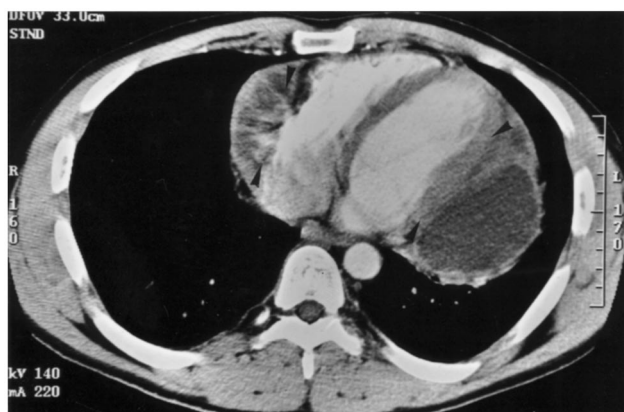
CT showed multiple masses adherent to the pericardium leading to severe compression of the left and right ventricle (arrow heads).
